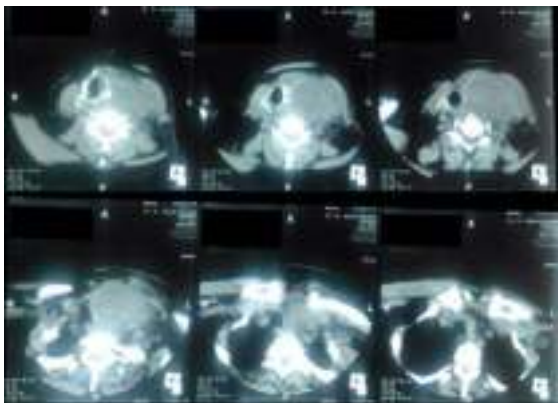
Computed tomography imaging of the neck
